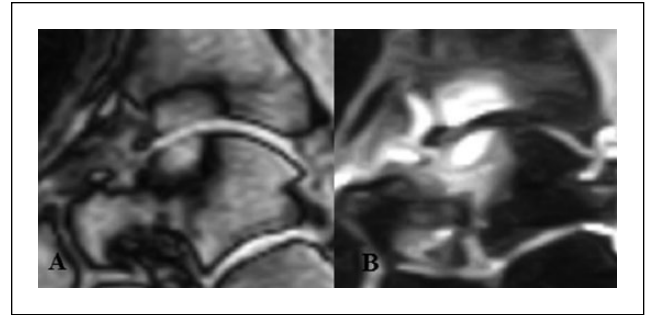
Preoperative MRI T1-sagittal (A) and STIR (B) scans of patient 2: the images show a large talar osteochondral lesion and a smaller lesion of the tibial plafond.
